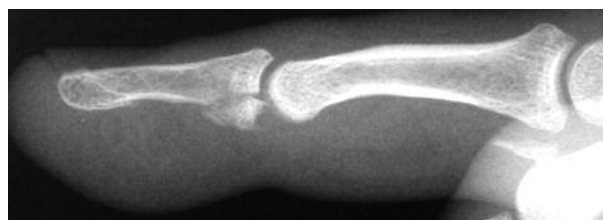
Lateral radiograph showing a Type IV FDP avulsion with fracture at the base of the distal phalanx with a further bony fragment attached to the tendon tethered at the proximal interphalangeal joint level.
